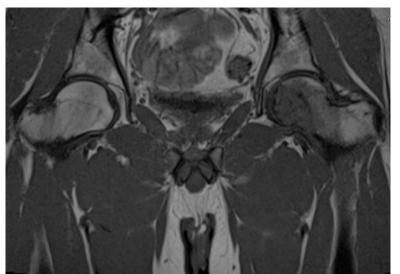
Preoperative coronal view MRI showing the lesion in the left femur
